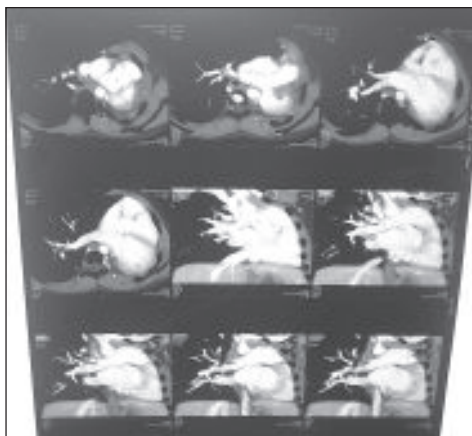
Pulmonary CT angiogram – Absent Lt pulmonary artery & features are consistent with Lt sided Pulmonary aplasia.*
